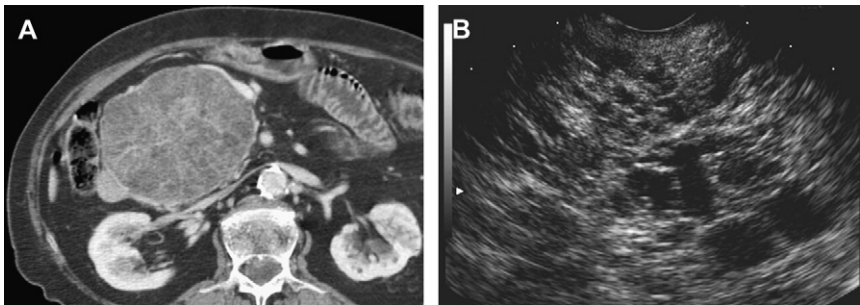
Eight-two-year-old woman who has a serous microcystic adenoma. (A) A contrast-enhanced CT scan shows a large spherical mass within the pancreatic head, having an appearance of a sponge, with innumerable tiny cystic spaces separated by thin, enhancing septa. (B) EUS confirms the innumerable tiny cystic spaces and septa. The patient had minimal symptoms related to the mass, and no surgery was performed.
